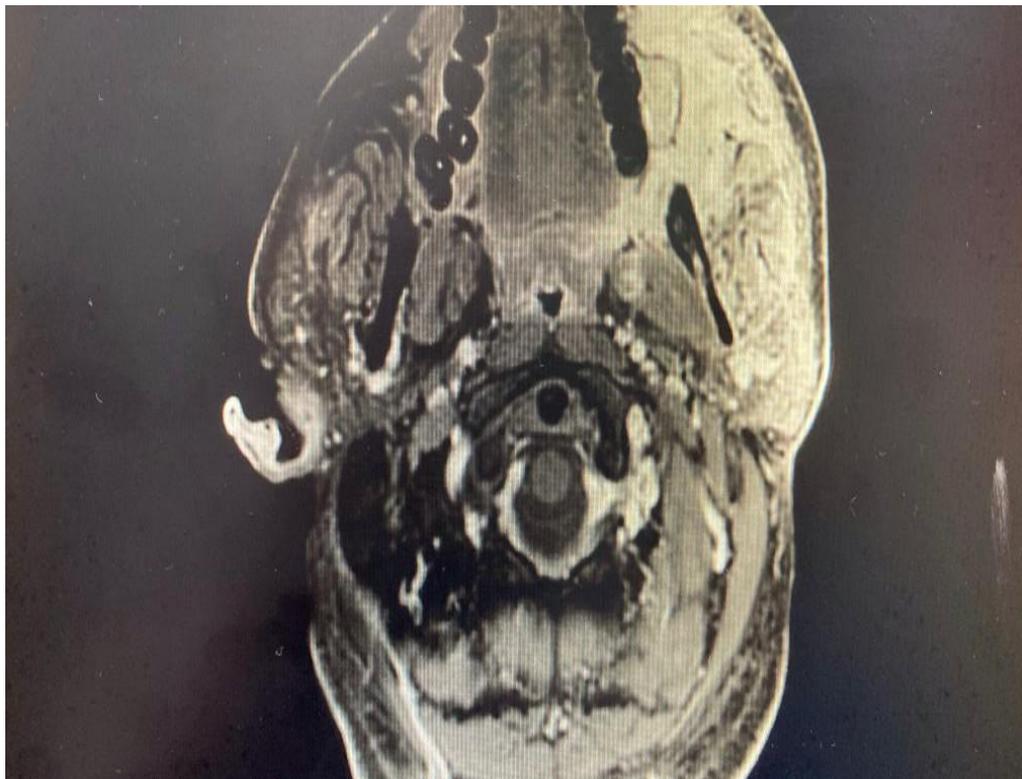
MRI post-surgery 8 weeks
